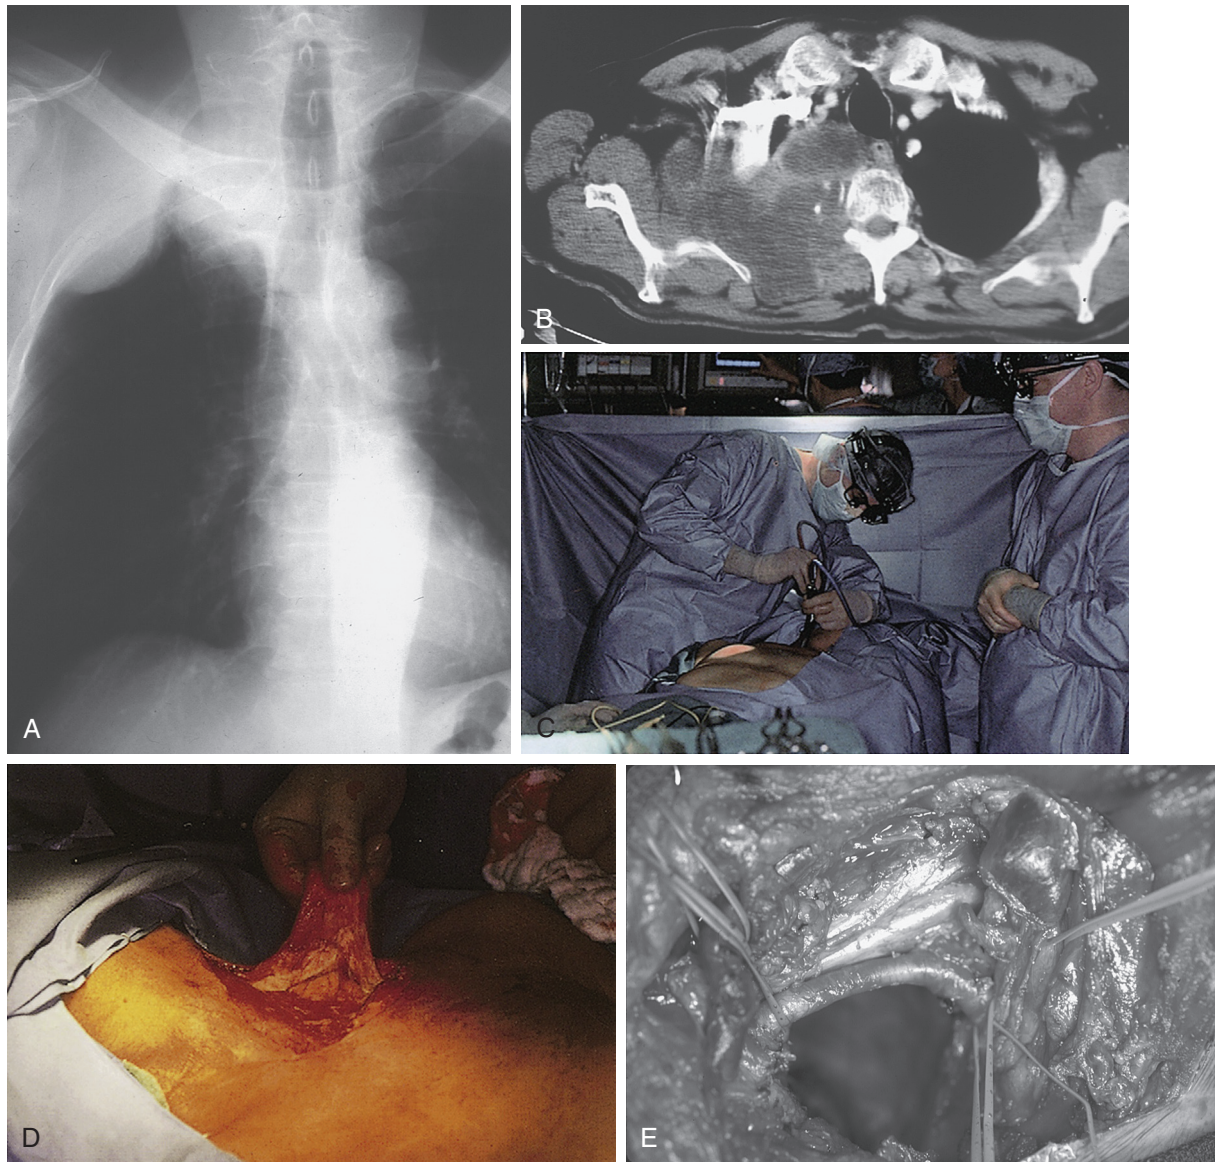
■ A, Chest radiograph demonstrating a large right upper lobe apical tumor, which was diagnosed a sarcomatoid carcinoma based on transthoracic needle biopsy. B, A CT scan demonstrates the full-thickness chest wall involvement with tumor extension into the posterior chest wall musculature. C, A mediastinoscopy is performed routinely to rule out N2 or N3 nodal involvement before proceeding with the extensive lung and chest wall resection. D, An initial supraclavicular neck dissection is performed to dissect the subclavian vessels and brachial plexus. This is the initial hockey-stick skin incision along the anterior border of the sternocleidomastoid muscle and along the clavicle. E, A close-up of the resection of the first and second ribs from the anterior approach with resection of the subclavian vein and preservation of the subclavian artery and brachial plexus as shown.
